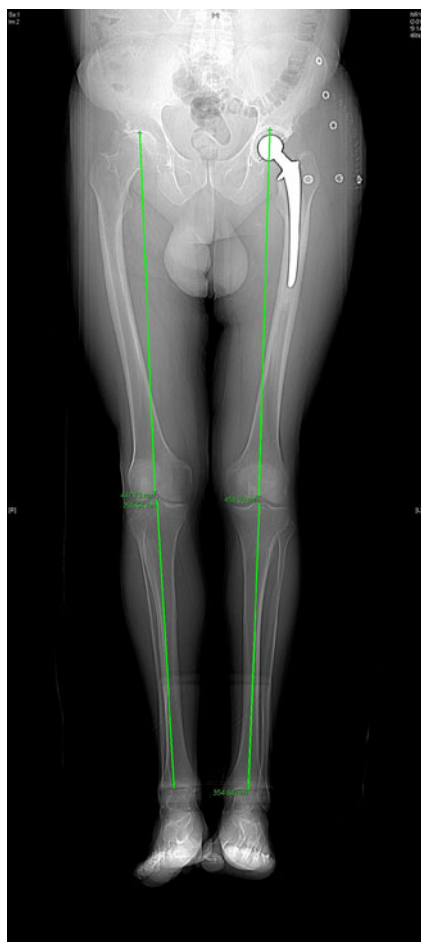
CT-scanogram measurement method. The LLD was defined as the difference in millimeters between the sum of the femoral and tibial lengths on the operated leg versus the contralateral side. The femoral length at the operated side was measured from the upper edge of the acetabular cup to the lower edge of the intercondylar notch and on the contralateral side from the top of the femoral head to the lower edge of the intercondylar notch. On both sides, the tibial length was measured from the center of the intercondylar eminence to the center of the tibial plafond
